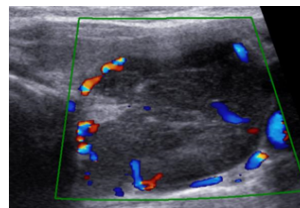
High Resolution Ultrasonography Of Neck : Hypoechoic mass lesion with peripheral and internal vascularity on left side – suggestive of left parathyroid adenoma.
